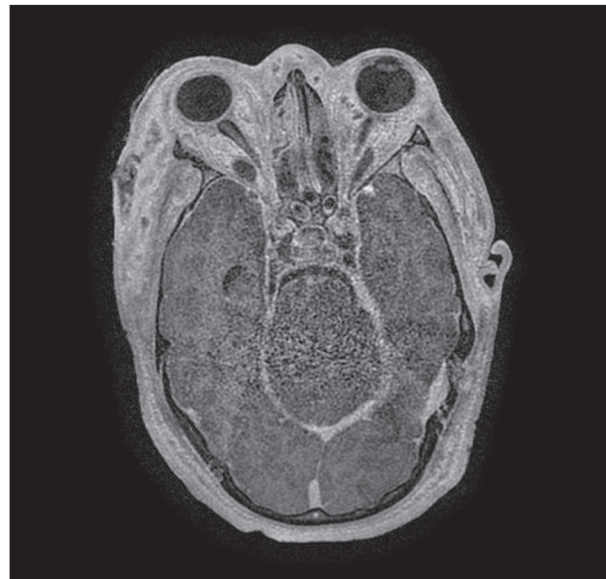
Axial T1-weighted magnetic resonance imaging with gadolinium contrast enhancement revealing a filling defect of both cavernous sinuses secondary to thrombus.
